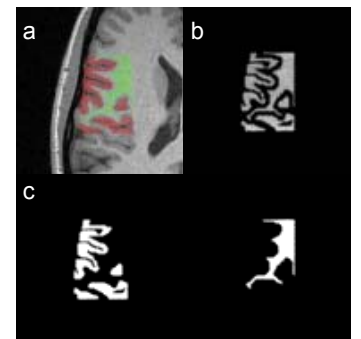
(a) WM/GM ROIs (green/red) defined using the underlying T1-weighted image of a healthy volunteer. (b) Real part profile image of the WM/GM ROI (both with positive polarity) and (c) sum and difference images of two acquisitions (+/+/-) to eliminate one of the contributions.
